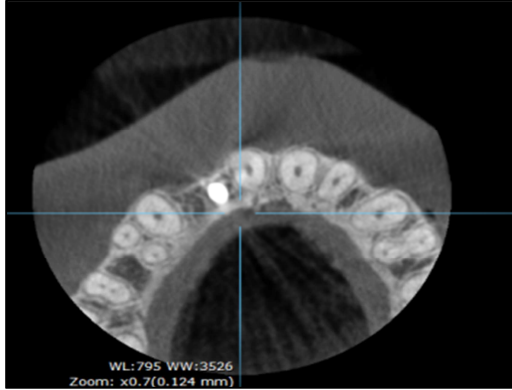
Axial view on CBCT after implant placement
